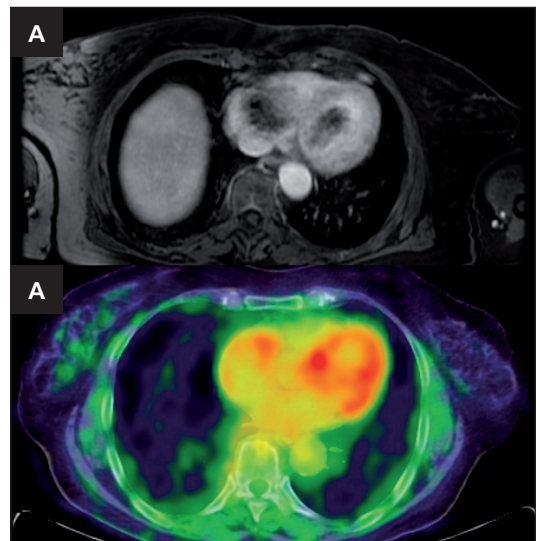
Contrast-enhanced CT revealing two hypodense and irregular cardiac masses, one on the right atrium (45×40 mm) and the other on the left ventricle (45×28 mm), in close relation with the interventricular septum, with mild and progressive contrast enhancement in late sequence acquisitions (A). Positron emission tomography (PET) using fluorodeoxyglucose (18F-FDG) revealing two hypermetabolic cardiac masses (B).
